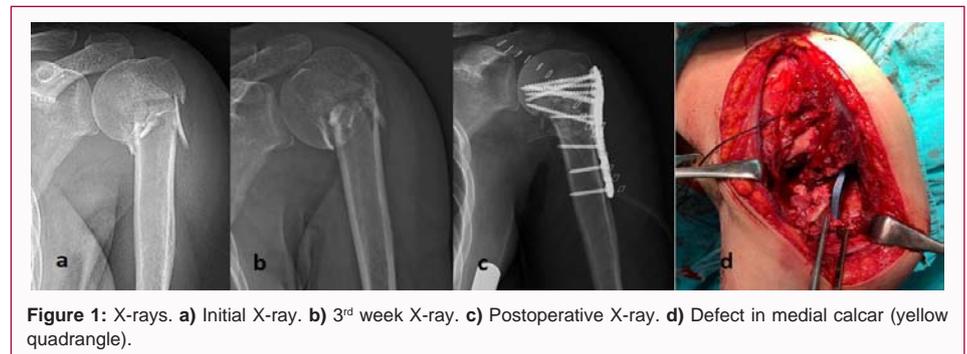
X-rays. a) Initial X-ray. b) 3<sup>rd</sup> week X-ray. c) Postoperative X-ray. d) Defect in medial calcar (yellow quadrangle).
